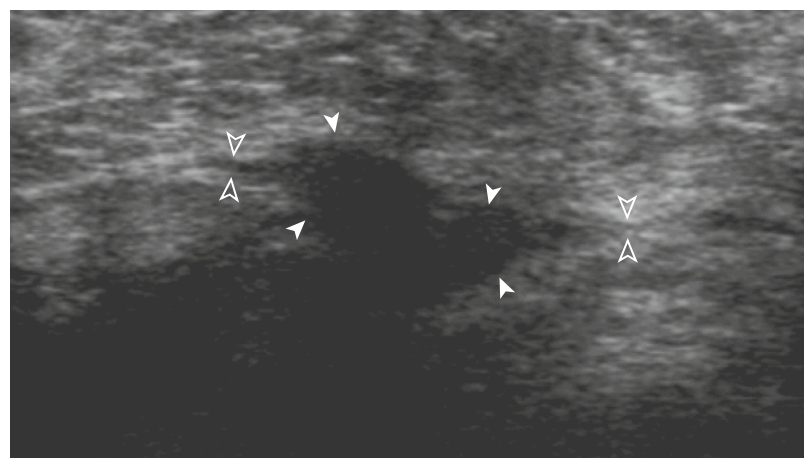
MORTON NEUROMA. Long-axis, 5- to 14-MHz ultrasound image over the third intermetatarsal space shows an elongated, hypoechoic, uncompressible neuroma (closed arrowheads) in continuity with the proximal and distal normal interdigital nerve (open arrowheads).
